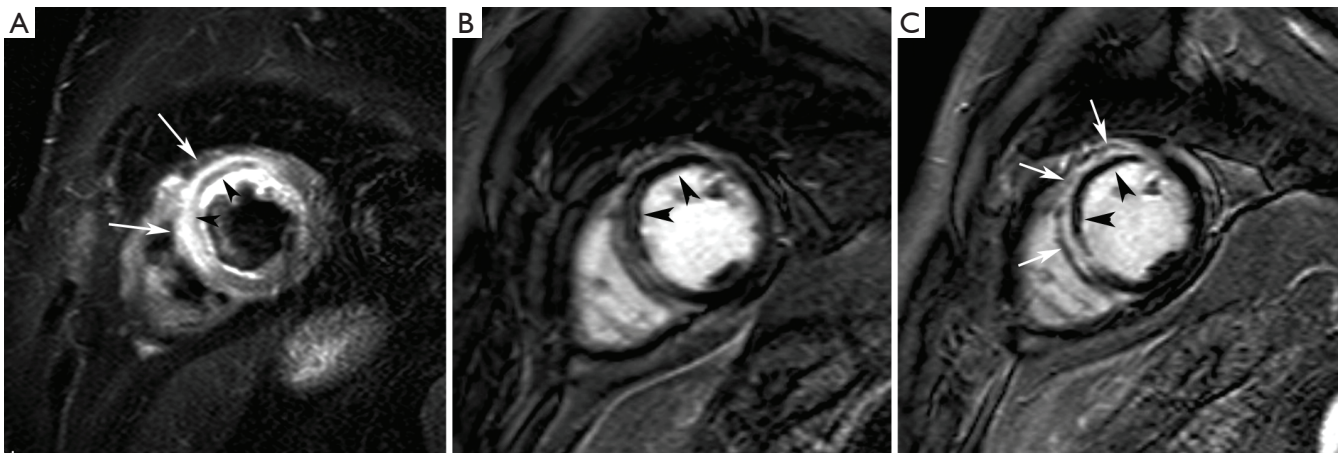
Hemorrhagic myocardial infarction. Short-axis T2-weighted STIR imaging (A), early gadolinium imaging (B) and late gadolinium imaging (C) in a patient with an extensive reperfused acute anteroseptal myocardial infarction. Presence of an extensive zone of myocardial edema in the LV anteroseptal wall (*arrows*, A) with evidence of concomitant myocardial hemorrhage (*arrowheads*, A). On early gadolinium imaging, a large zone of microvascular obstruction is present (*arrowheads*, B). At late imaging, a significant shrinkage of the microvascular obstruction has occurred (*arrowheads*, C) while the infarct has substantially become enhanced (*arrows*, C). Adapted from *Ischemic Heart Disease* by Bogaert J and Dymarkowski S, in *Clinical Cardiac MRI Second Edition*, Bogaert J, Dymarkowski S, Taylor AM, Muthurangu V (eds). Springer Heidelberg, Germany (ISBN 978-3-642-23034-9)
